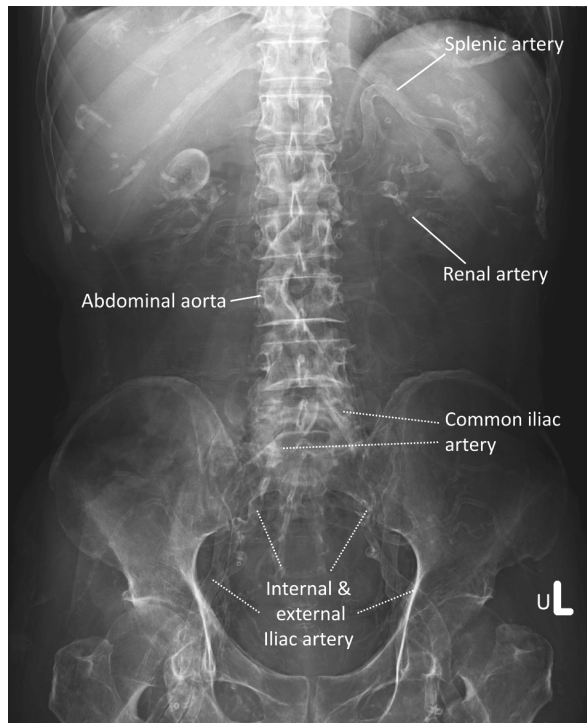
Abdominal plain radiograph revealing diffuse noticeable vascular calcification involving the abdominal aorta, splenic, bilateral renal, mesenteric, common iliac as well as external and internal iliac arteries.
